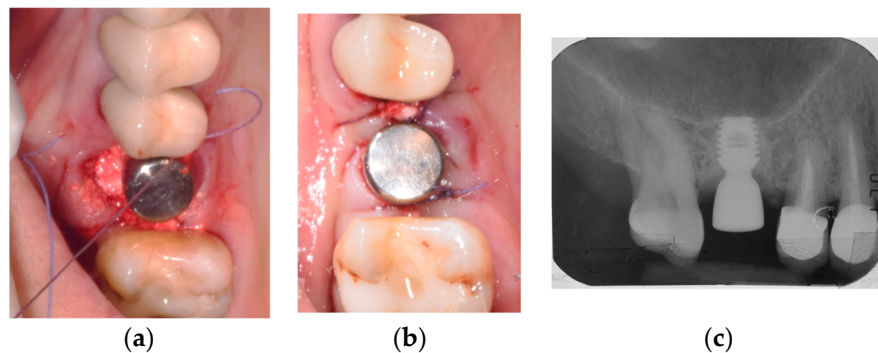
Intra-operative application of temporary healing abutment and defect filling with bone graft composed of Bio-Oss and Bond-Bone (a), clinical view of sutures (b), and post-operative radiograph after wound closure (c).
